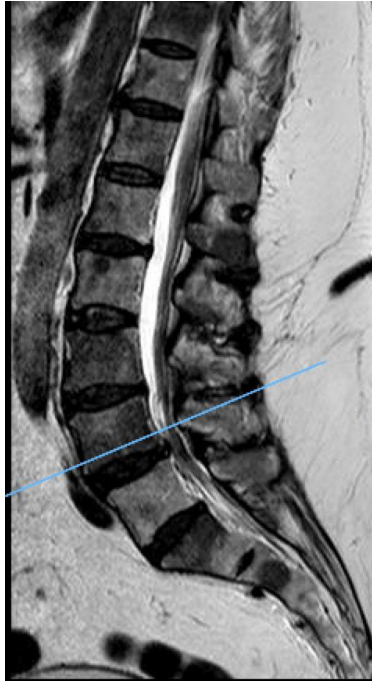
Lumbar spine MRI without contrast in June 2024.
